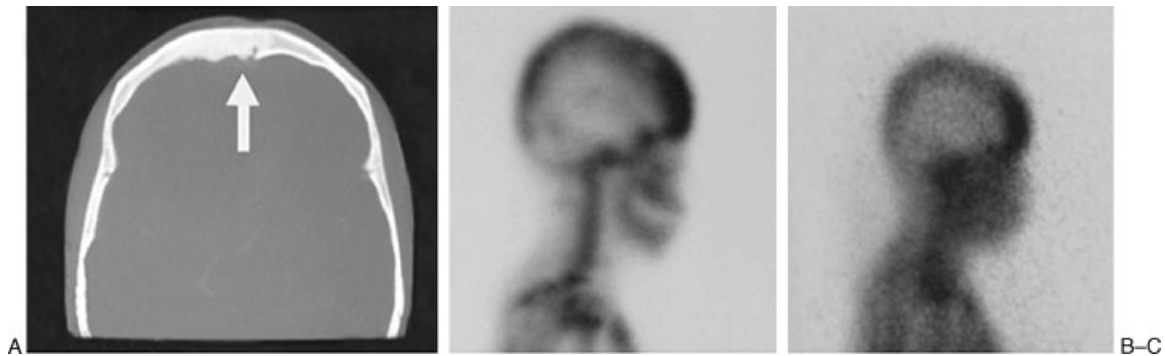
(A) A CT scan with frontal sinus inflammation. (B) Scintigraphy with inflammatory activity and osteomyelitis (^{99m}Tc). (C) Scintigraphy with inflammatory activity and osteomyelitis (⁶⁷Ga).
